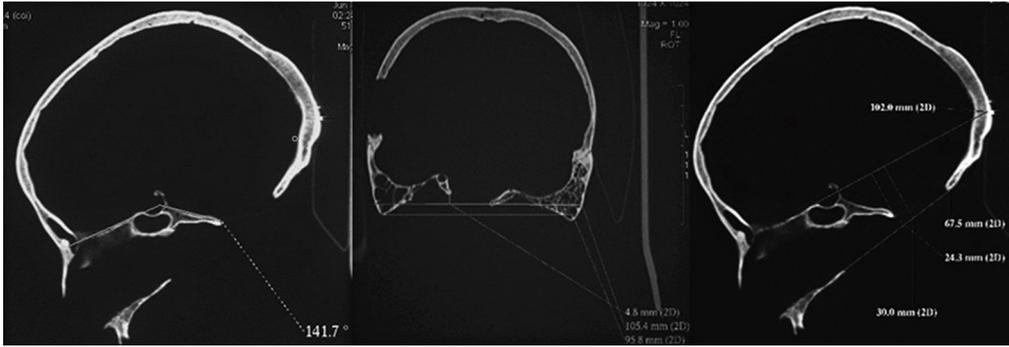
CT scans based measurements
